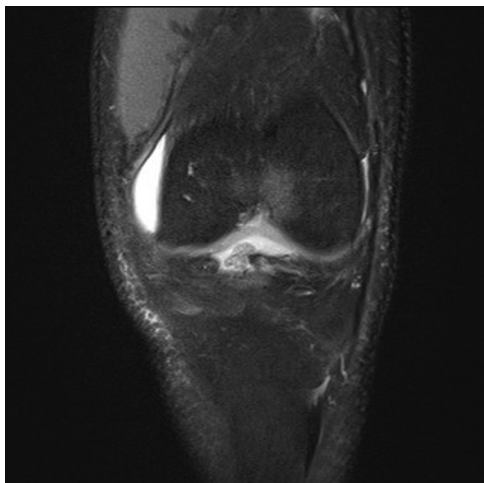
Coronal section of a follow-up magnetic resonance imaging.
